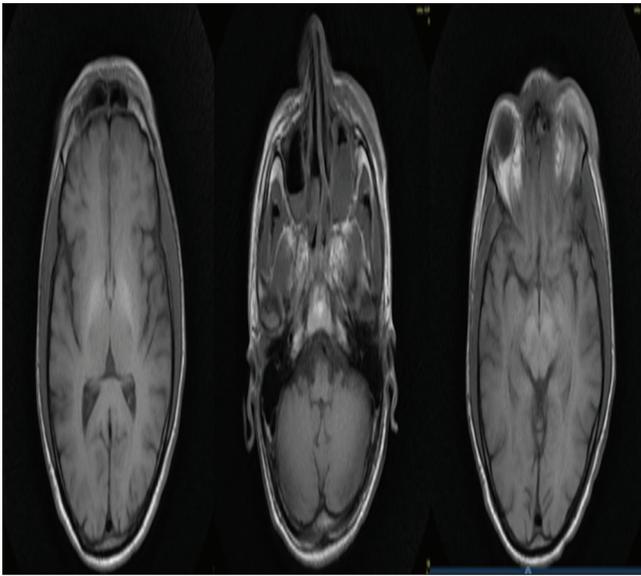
MRI brain scan with contrast. Conclusion: A case of invasive sinonasal mucormycosis showing orbital and cerebral extension. Orbital involvement: Periorbital and orbital cellulitis as described. No intraorbital abscess formation. Intracranial involvement: Regional focal bilateral frontal lobe early cerebritis as described likely due to perineural spread along olfactory nerve root. No current evidence of intracerebral abscess formation. MRI: Magnetic resonance imaging
